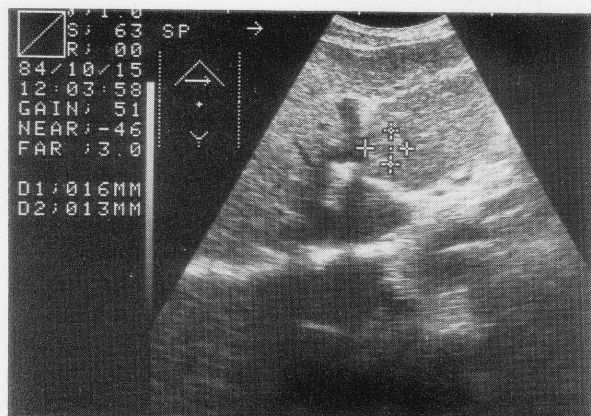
Hepatic sonogram revealed a hyperchoic lesion in the left lateral segment.
